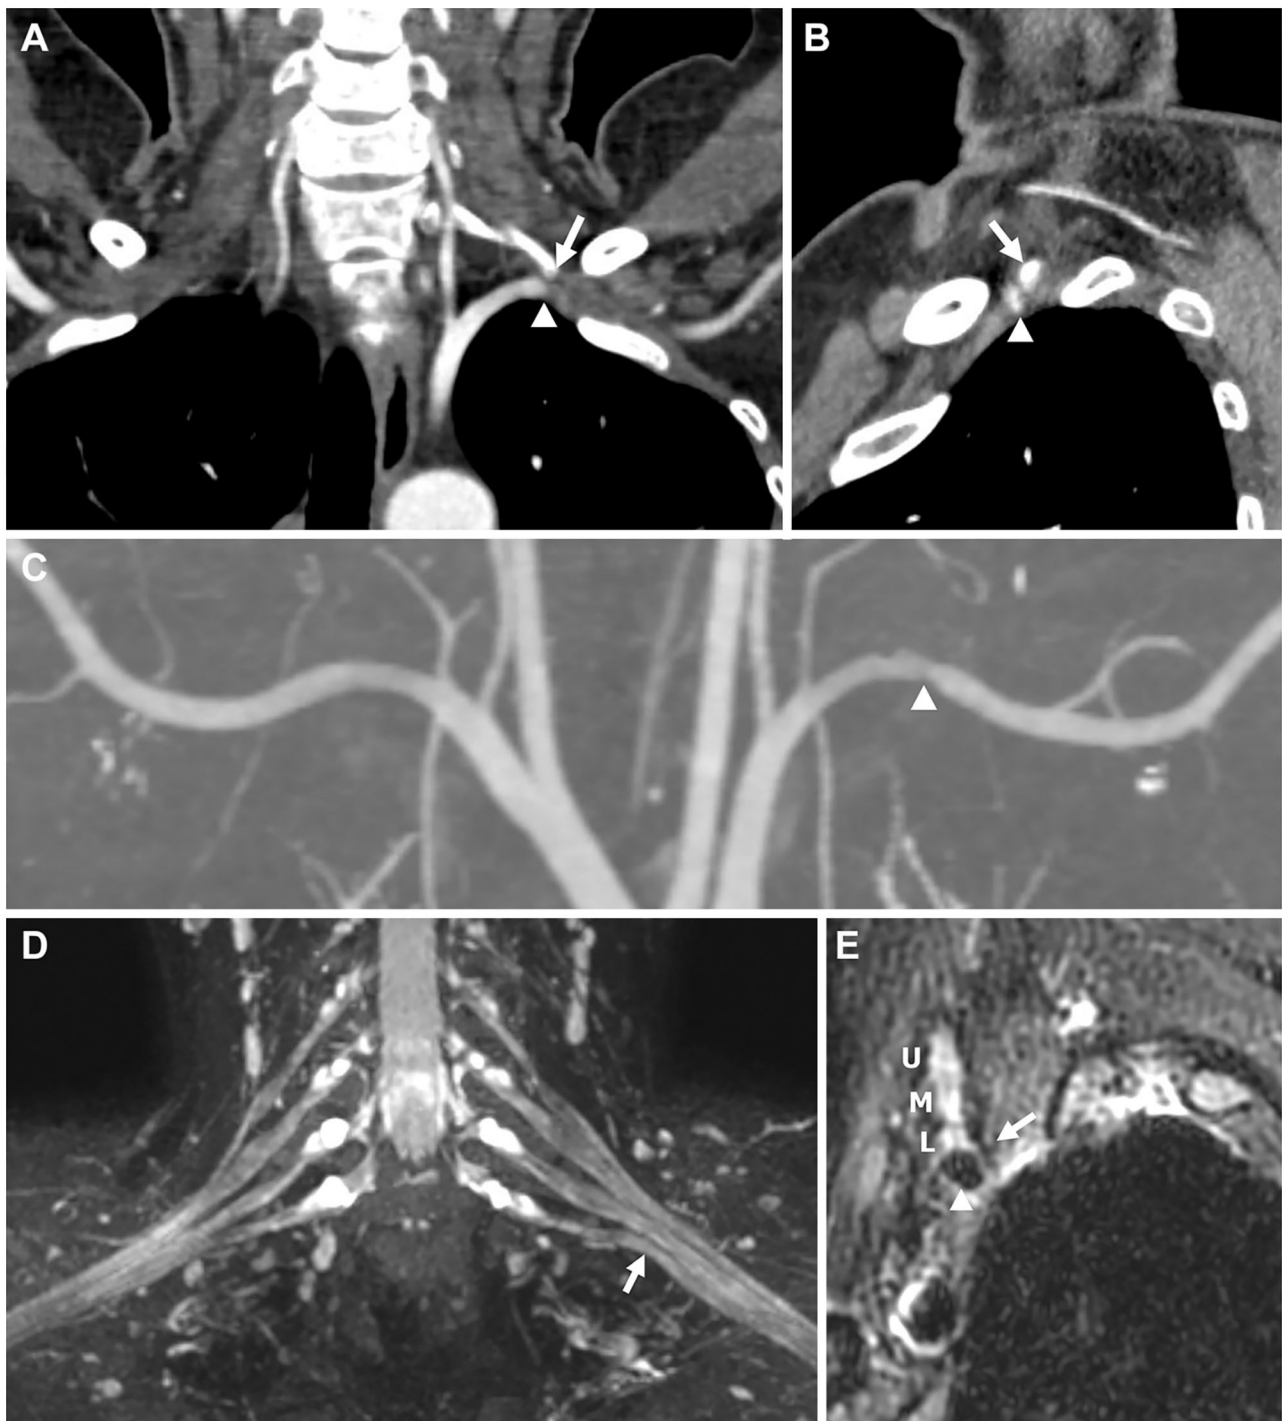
Imaging findings for Patient 1. (A,B) Computed tomography (CT) angiography performed with 180° shoulder abduction. (C–E) Brachial plexus magnetic resonance imaging (MRI). (A) Coronal image showing the tip of the left cervical rib arising from the C7 vertebra (arrow) abutting the left subclavian artery (arrowhead). (B) Sagittal image showing the tip (arrow) compressing the subclavian artery (arrowhead) in the anterior direction, causing stenosis. (C) Coronal maximum intensity projection (MIP) image showing stenosis of the left subclavian artery (arrowhead). (D) Coronal T2-weighted fat suppression MIP image showing upward angulation of the lower trunk (arrow), presumably caused by the anterior tip of the cervical rib, although not shown in this image. Swelling or abnormal signal intensity of the brachial plexus was not definite. (E) Oblique sagittal T2-weighted fat suppression image showing the spatial associations of the anterior tip of the cervical rib (arrow), brachial plexus (U, upper trunk; M, middle trunk; L, lower trunk), and subclavian artery (arrowhead).
